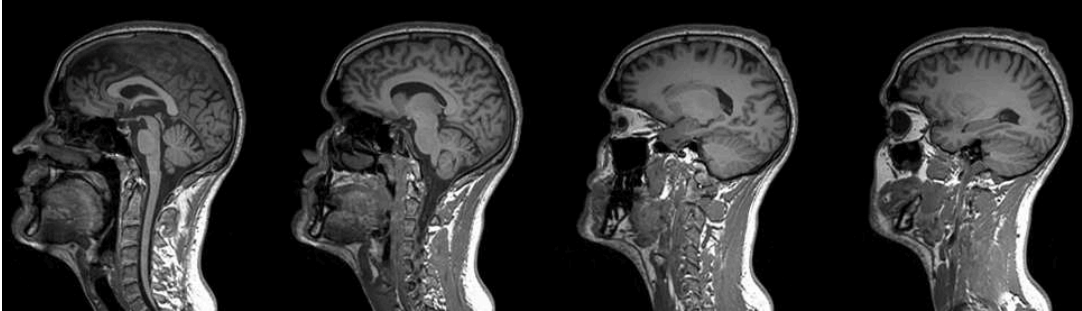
MRI-data set (selected slices) used for model generation.
